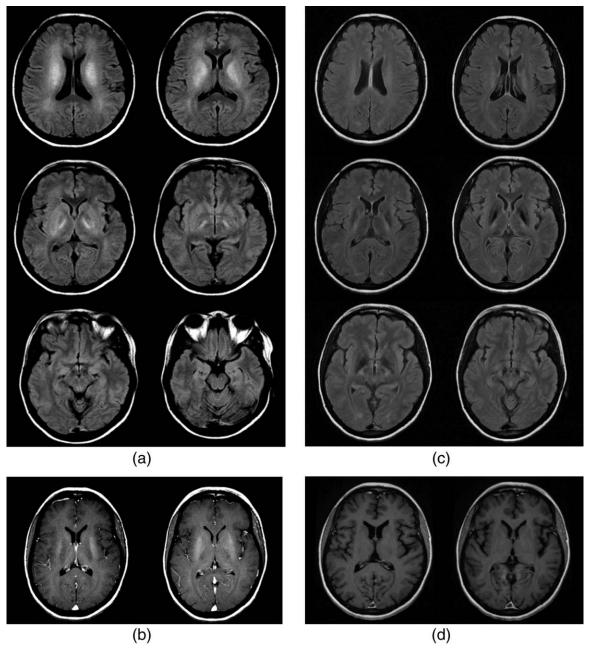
(Case 1): Axial flair MRI: Increased signal changes in the globus pallidus, putamen and internal capsule, extending into the subthalamic region. B (Case 1): Axial MRI post-contrast: Bilateral putamenal enhancement. C (Case 1): Repeat axial flair brain MRI (8 months after initial scan) showing improvement in high signal changes. D (Case 1): Repeat axial brain MRI postcontrast (8 months after initial scan) showing resolution of putamenal enhancement.
